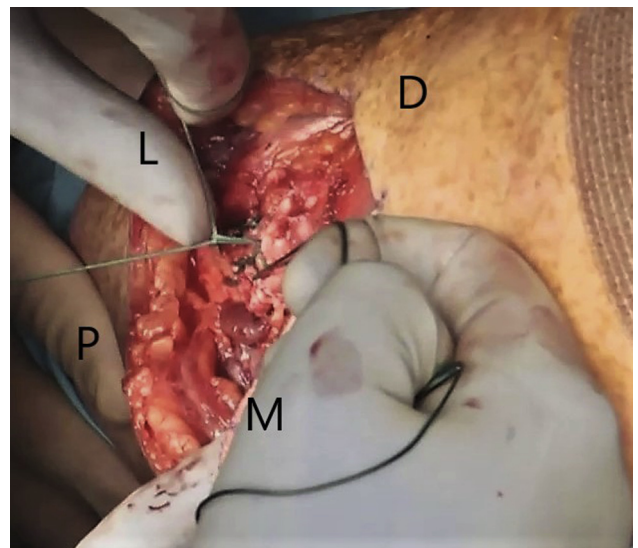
The free end of the lateral suture is passed from deep to superficial within the tendon. This post limb along with the limb that was run proximally and distally in the tendon should both be exiting the dorsal surface of the tendon (CT, central tunnel; D, distal; L, lateral; LT, lateral tunnel; M, medial; MT, medial tunnel; P, proximal.)
